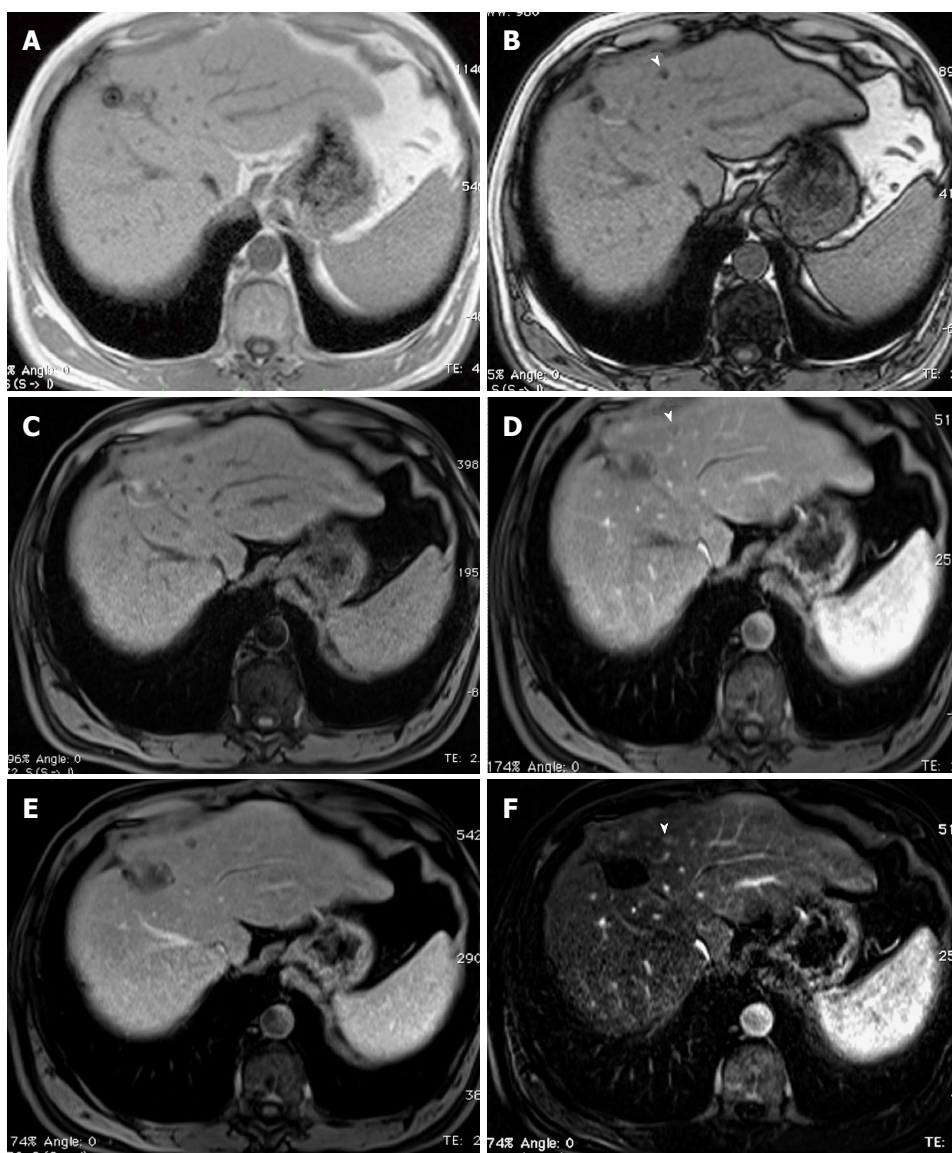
Small fat-containing hepatocellular carcinoma; the value of subtraction images. A: In-phase; B: Opposed-phase GRE T1 weighted images; C-E: Pre- and post-contrast fat-suppressed 3D-GRE T1-weighted images during the (D) late hepatic arterial and (E) delayed phases; F: Post-processed subtractions arterial phase image. There is a small left hepatic nodule, which demonstrates drop of signal intensity on opposed-phase (arrowhead, B) and pre-contrast images (C) compared to the in-phase images (A), suggesting the presence of fat, with possible minimal increased arterial enhancement (arrowhead, D), confirmed on subtraction images (arrowhead, F), and washout on delayed images (E) in keeping with a small fat-containing hepatocellular carcinoma. GRE: Gradient recalled echo.
